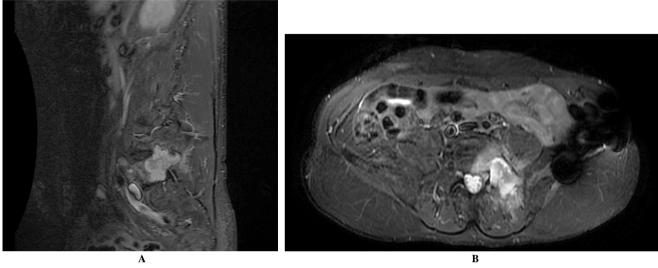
A & B) Preoperative MRI STIR-sequences showing an hyperintense mass of the left hemivertebral of L5 with presence of edema extended until hemivertebral body of L5.
